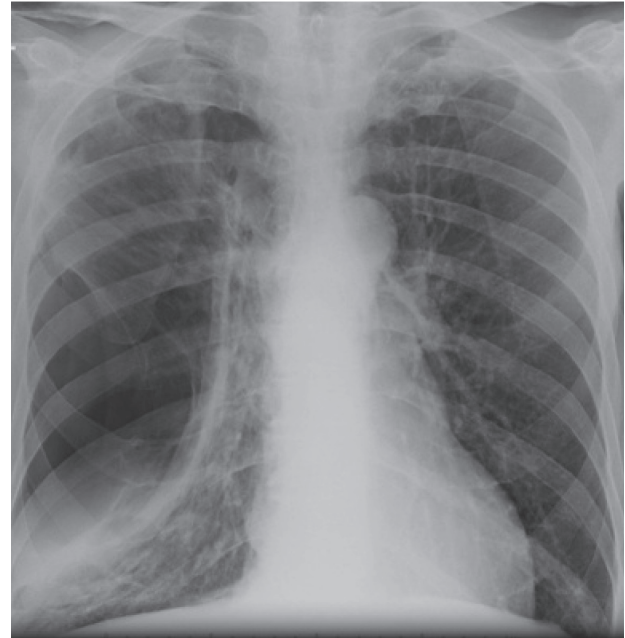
X-ray chest postero-anterior view showing loculated pneumothorax.
